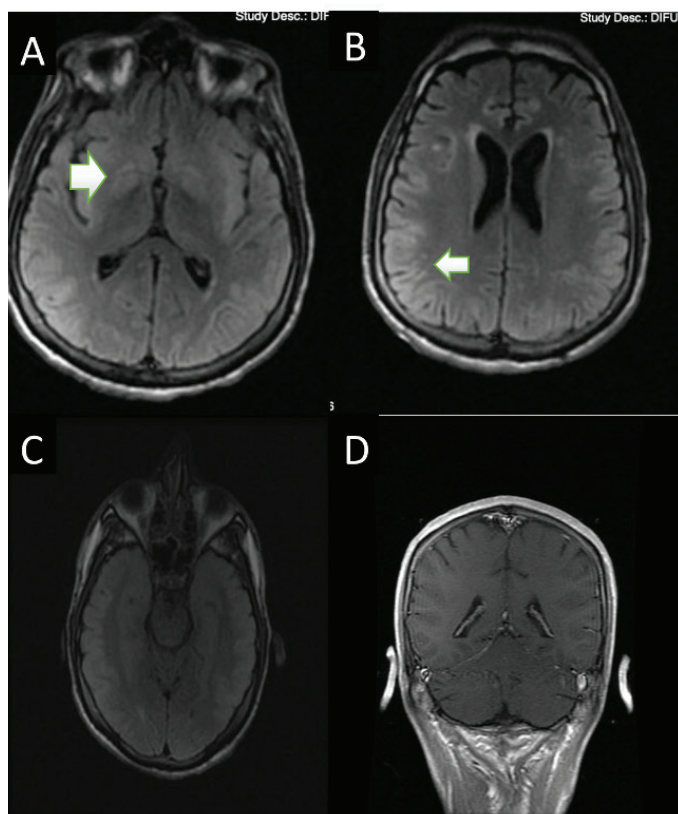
A, B, C, D) T2, T1 weighted and FLAIR images show hyperintensities and new contrast enhancement involving bilateral parieto-temporal cortical areas and basal ganglia
